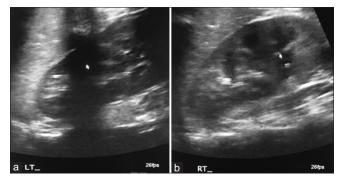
A 10-month-old female infant with primary cervical neuroblastoma who presented with palpable neck mass. (a) Longitudinal sonographic images of left suprarenal region confirm absence of abdominal adrenal mass. (b) Longitudinal sonographic images of right suprarenal region confirm absence of abdominal adrenal mass.
